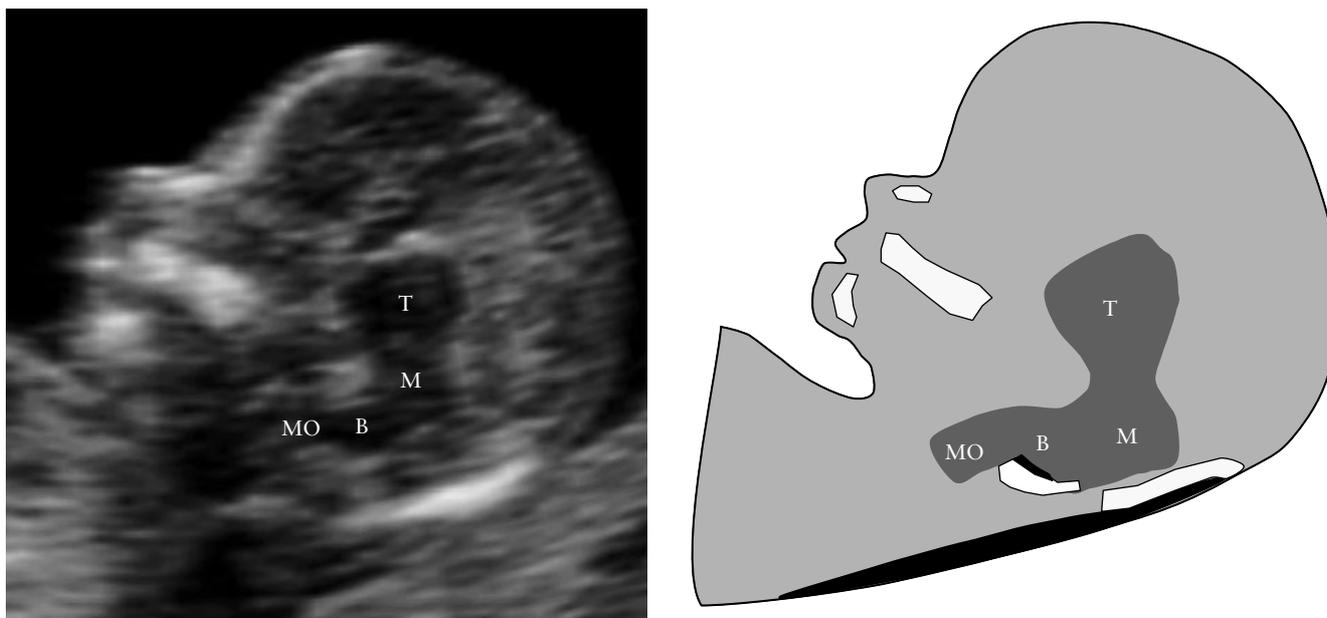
Ultrasound image in the mid-sagittal plane of the fetal face in a case of open spina bifida demonstrating compression of the fourth ventricle with no visible translucency. B, brain stem; M, midbrain; MO, medulla oblongata; T, thalamus.
